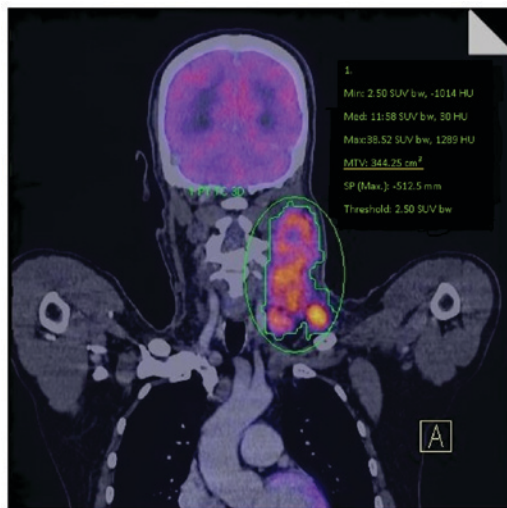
MTV assessment. MTV was measured using a SUV-based automated counting program. The margins of the tumor were drawn in order to incorporate each target lesion in the axial, coronal and sagittal ^{18}F -FDG PET/CT images. MTV, metabolic tumor volume; SUV, standardized uptake value.
